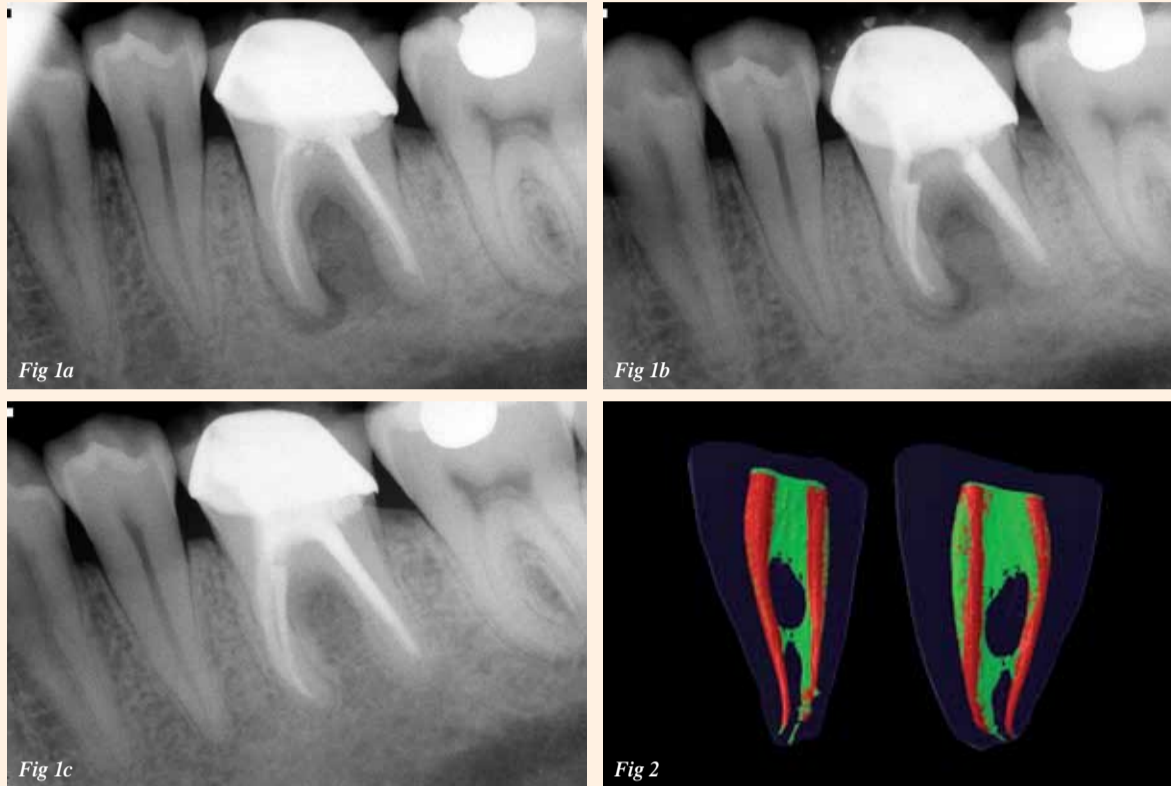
Tooth #19 shows a radiolucent periapical lesion around the mesial root apex and into the furcation.—Fig. 1b: Post-op radiograph.—Fig. 1c: One-year follow-up radiograph. (Courtesy of Dr Brett E. Gilbert)—Fig. 2: The unprepared pulp tissue (green) and the post-op prepared or instrumented areas (red), showing the complexity of the root-canal anatomy and the difficulty in completely cleansing the root-canal system. (Courtesy of rootcanalanatomy.blogspot.com)
